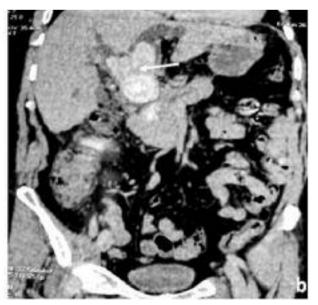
Abdominal CT-scan (a. axial, b. coronal reconstruction): A giant staghorn common bile duct lithiasis (arrows), measuring 9 x 4.5 cm conforming in shape to the common bile duct.
